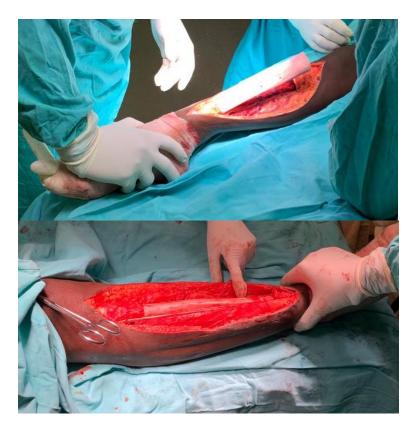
Intraoperative pictures and postoperative radiograph. Figure 3A shows liquid nitrogen-treated autograft. Figure 3B shows the plate fixation of the autograft and Figure 3C shows the immediate post-operative radiograph (AP & Lateral) showing perfect reduction and fixation.
